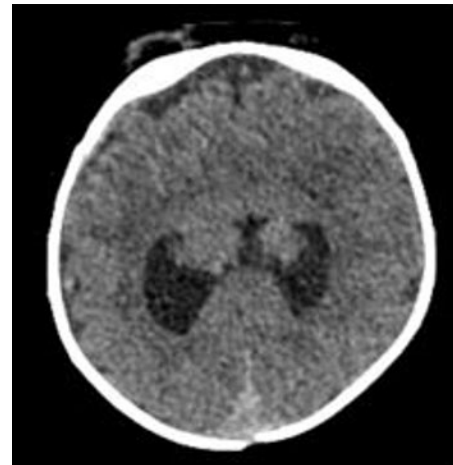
Axial CT image showing partial interhemispheric fissure and midline fused lateral ventricles with absent anterior horns.
